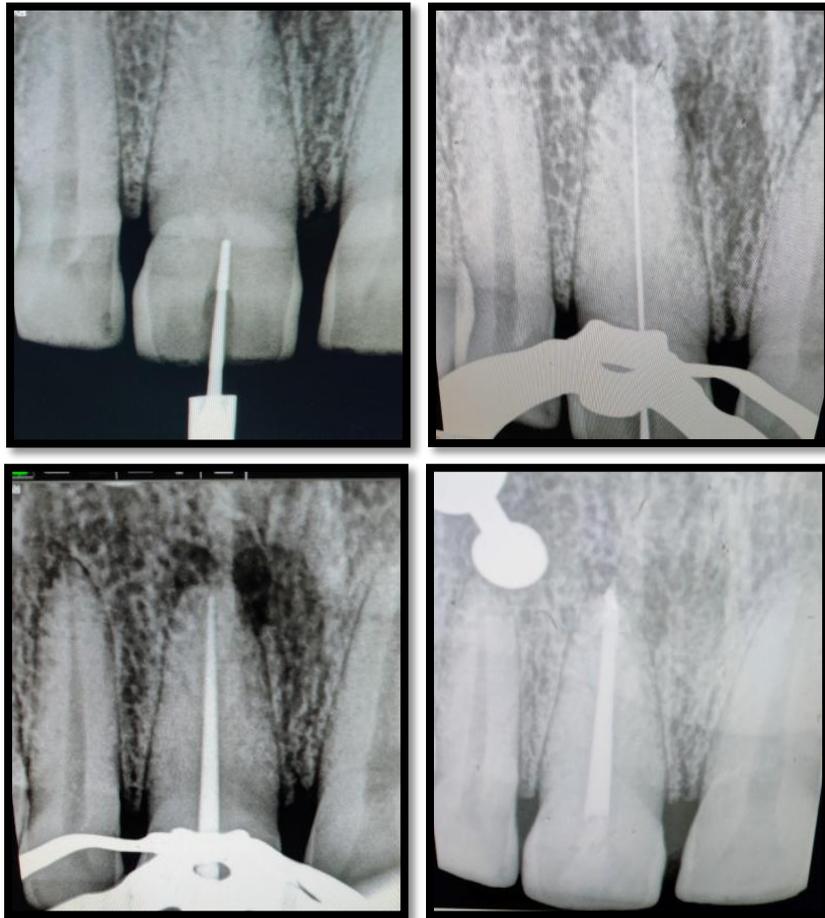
INTRAOPERATIVE AND POSTOPERATIVE RADIOGRAPHS
